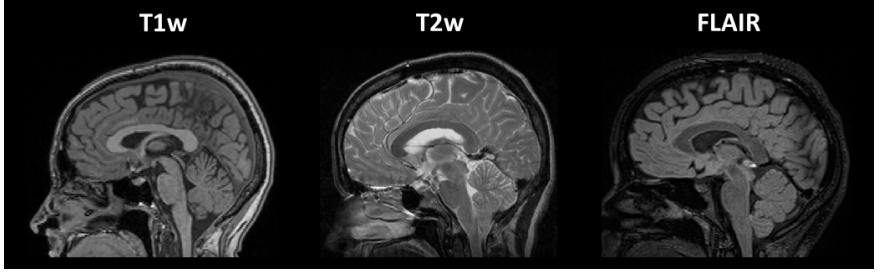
Comparison of T1w, T2w and FLAIR MRI scans.
